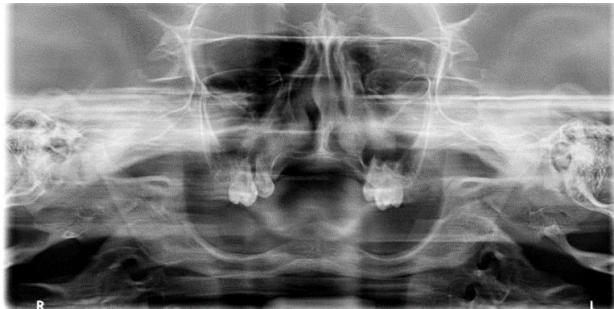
Orthopantomograph of patient showing absence of tooth buds.
